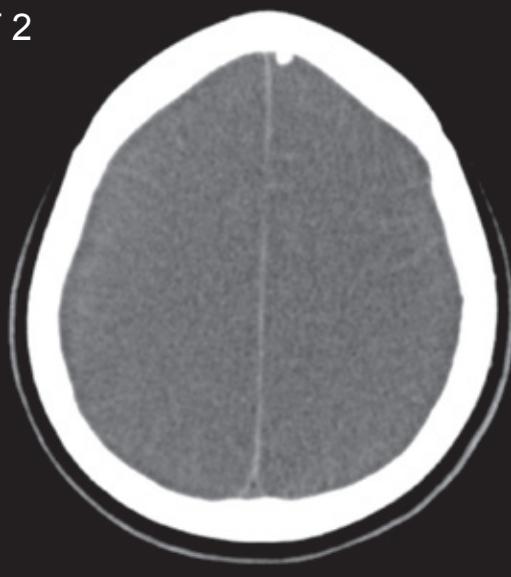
Axial CT sections from the initial and subsequent CT studies demonstrating progression of the cerebral oedema and development of hyperdense sulcal spaces ('pseudo-subarachnoid haemorrhage' sign).
